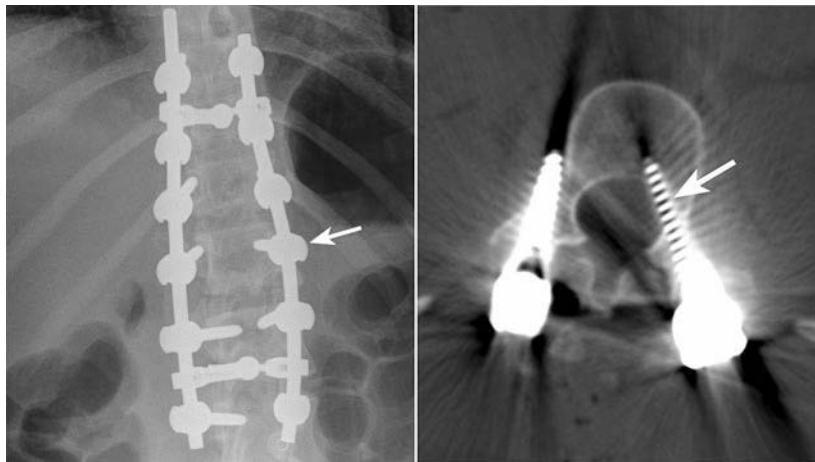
Radiographic film (left) showing a normal screw placement denoted by the arrow, with the computed tomographic scan (right) showing a medial misplacement, denoted by the arrow.
